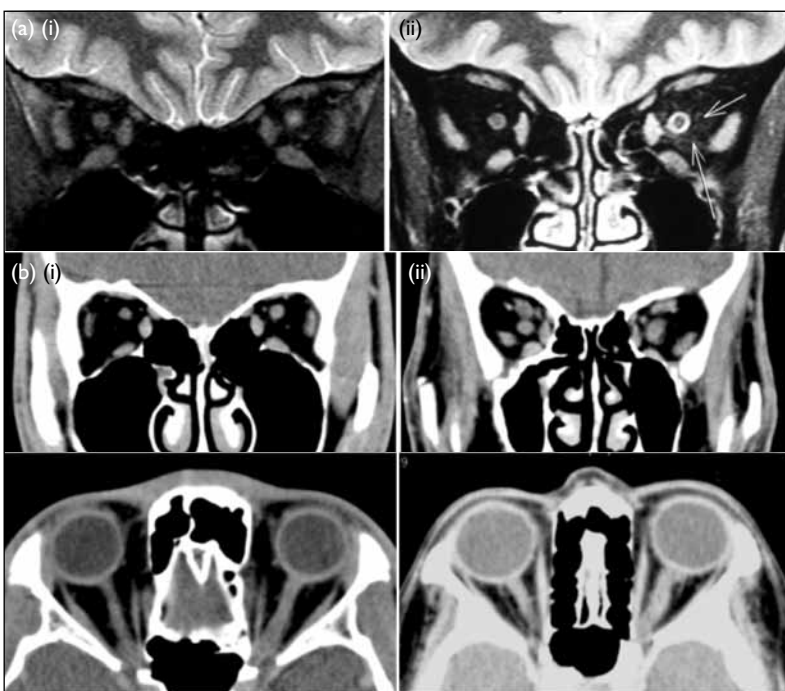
(a) Magnetic resonance imaging (coronal short-T1 inversion recovery images) of the orbit in patients with (i) left optic neuritis showing hyperintensity of the optic nerve, and (ii) left optic perineuritis showing perineural hyperintensity around the left optic nerve with dirty fat sign depicted with arrows. (b) Comparison of contrast computed tomographic images of patients with (i) optic neuritis and (ii) optic perineuritis. Coronal and axial scans of the patient with left optic neuritis show an enlarged and contrast-enhancing left optic nerve. In the patient with left optic perineuritis, there is streaky enhancement of perineural tissue (dirty fat sign) which is not evident in optic neuritis
